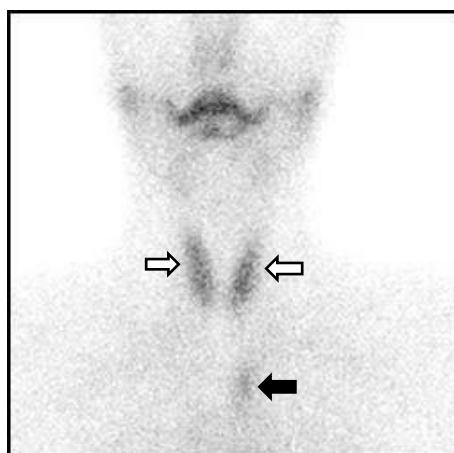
Thyroid gland scintigraphy performed with technetium-99m pertechnetate showing normal radionuclide uptake by the gland (white arrows) and uptake by the ectopic thyroid tissue in the upper mediastinum on the left side (black arrow).
